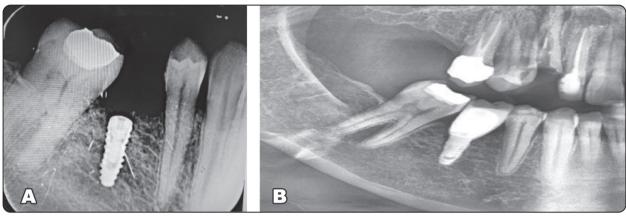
A radiograph shows the implant immediate after placement at base line(A), and implant with final prosthetic crown at 4 months post-operative(B).
